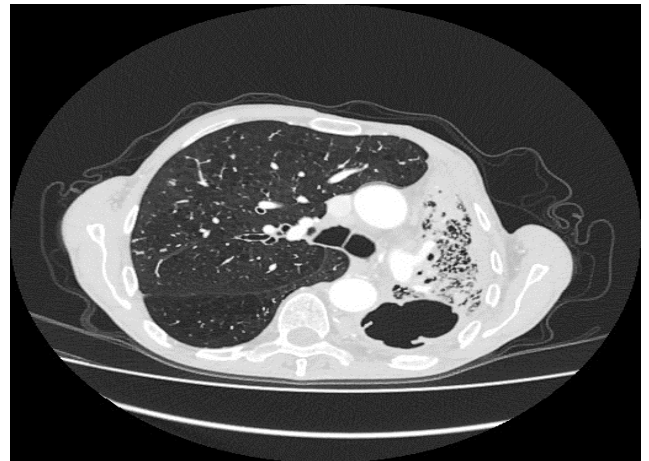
Patient I (chest CT scan).
